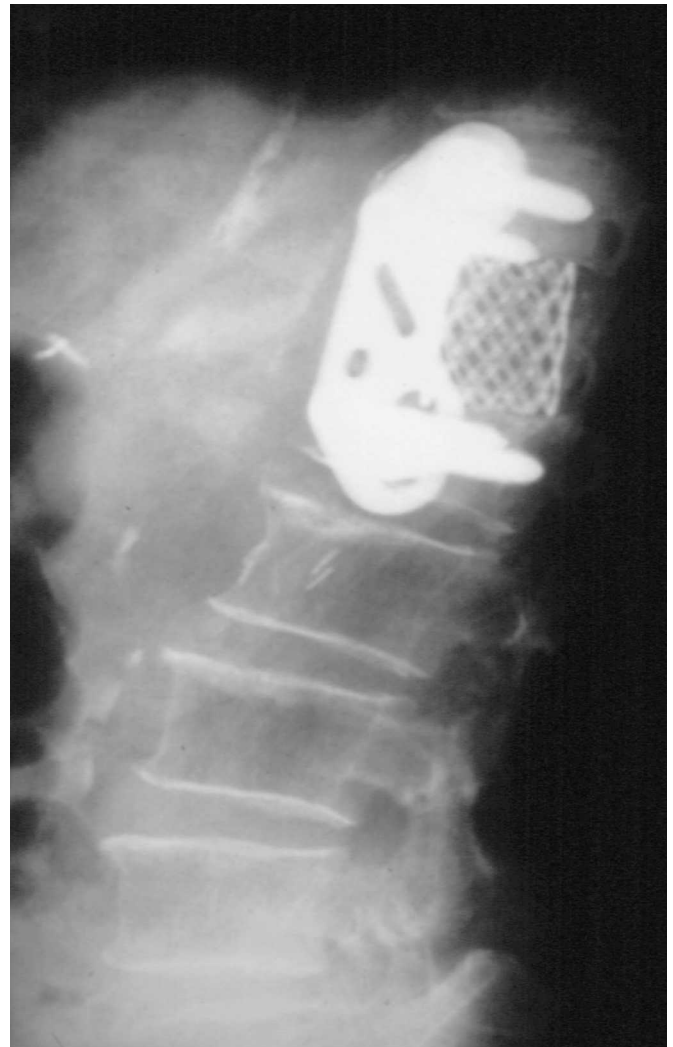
Lateral postoperative radiographs shows corpectomy of T12 and reconstruction with titanium cage and anterior plate in the patient shown in Figure 2.
